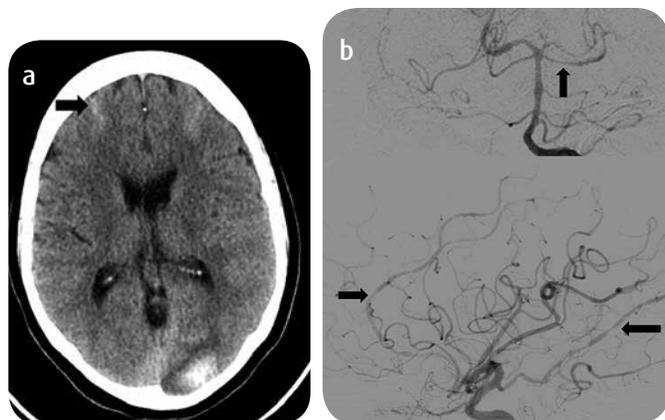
a) CT of simple skull: subarachnoid hemorrhage in the convexity. b) Arteriography: bleeding of aneurysmal origin is ruled out and a diffuse decrease in vascular diameter is observed in the posterior cerebral arteries, superior cerebellum, posterior communicator, middle cerebral and pericallose arteries.
